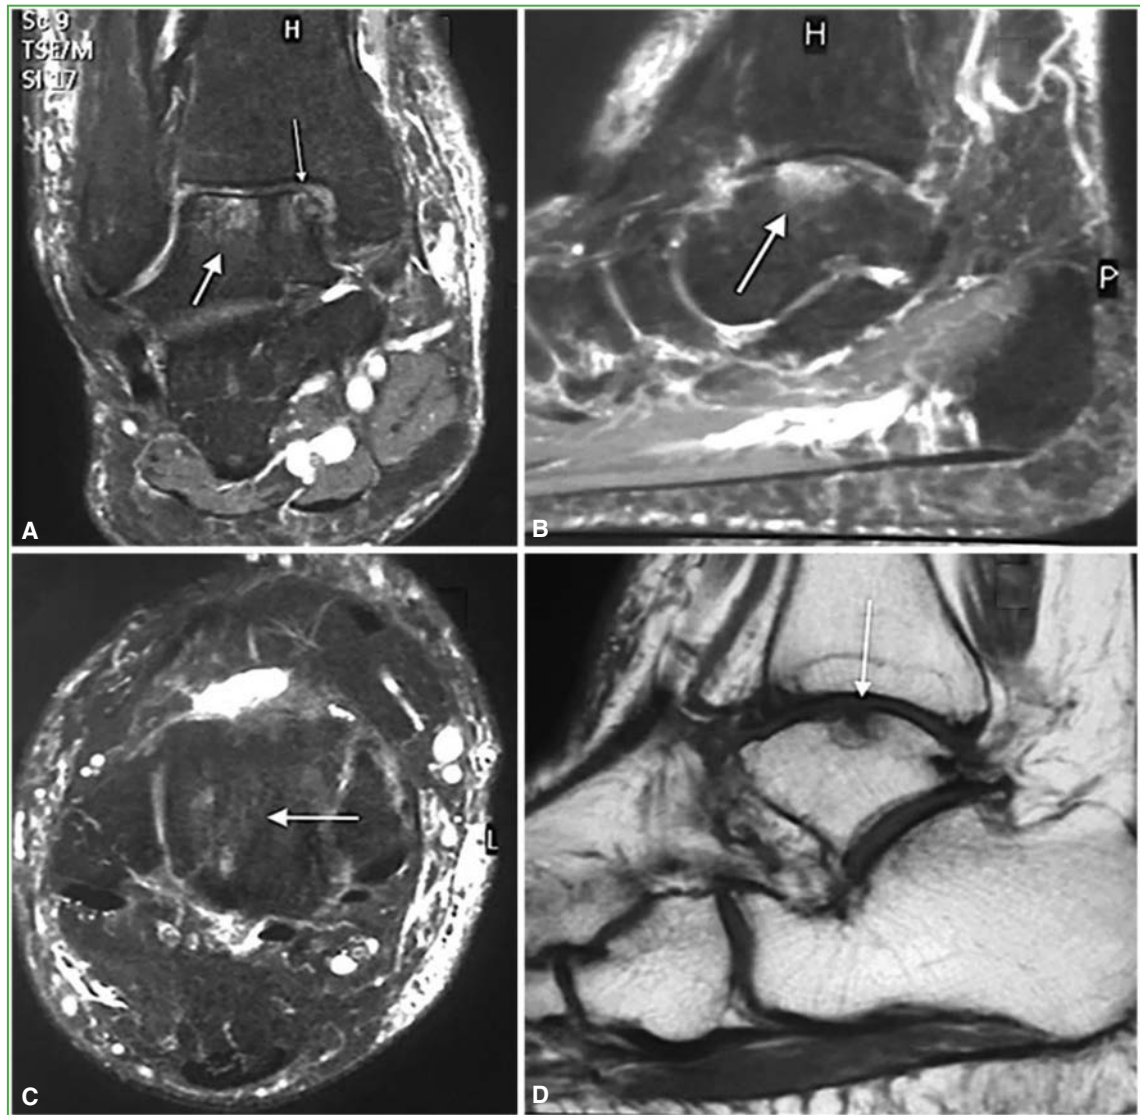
T2-weighted magnetic resonance images of the ankle and hindfoot obtained at the 36-month follow-up. A. Coronal image. B. Sagittal image. C. Axial image. The arrows indicate improvement of the bone marrow edema and osteochondral lesion. D. Sagittal T1-weighted image. Improvement of the articular surface of the talar dome is observed.
